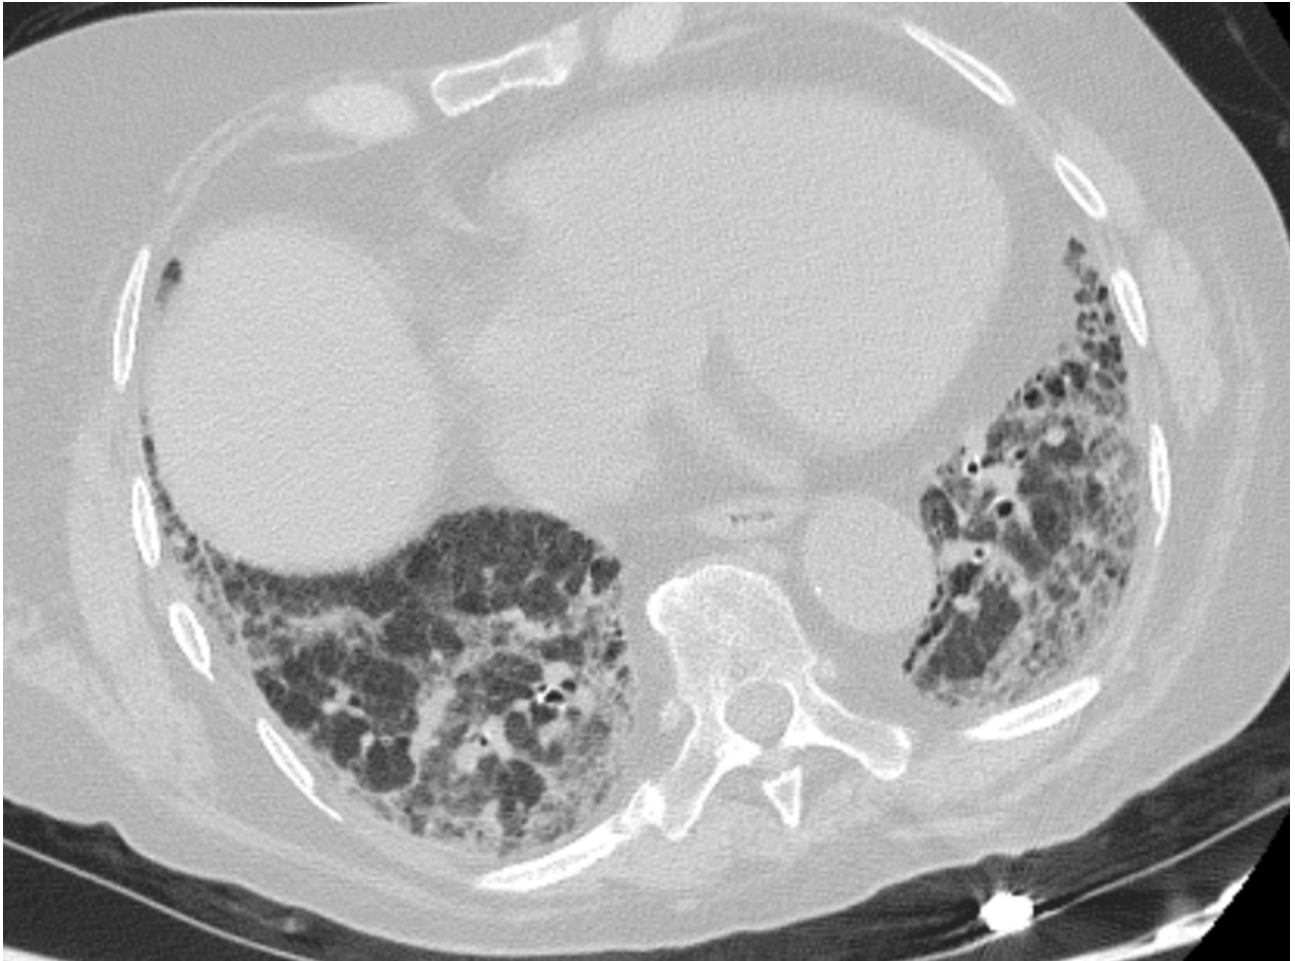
High resolution computed tomography (HRCT): advanced IPF, without pleural effusion or mediastinal lymphadenopathy.
